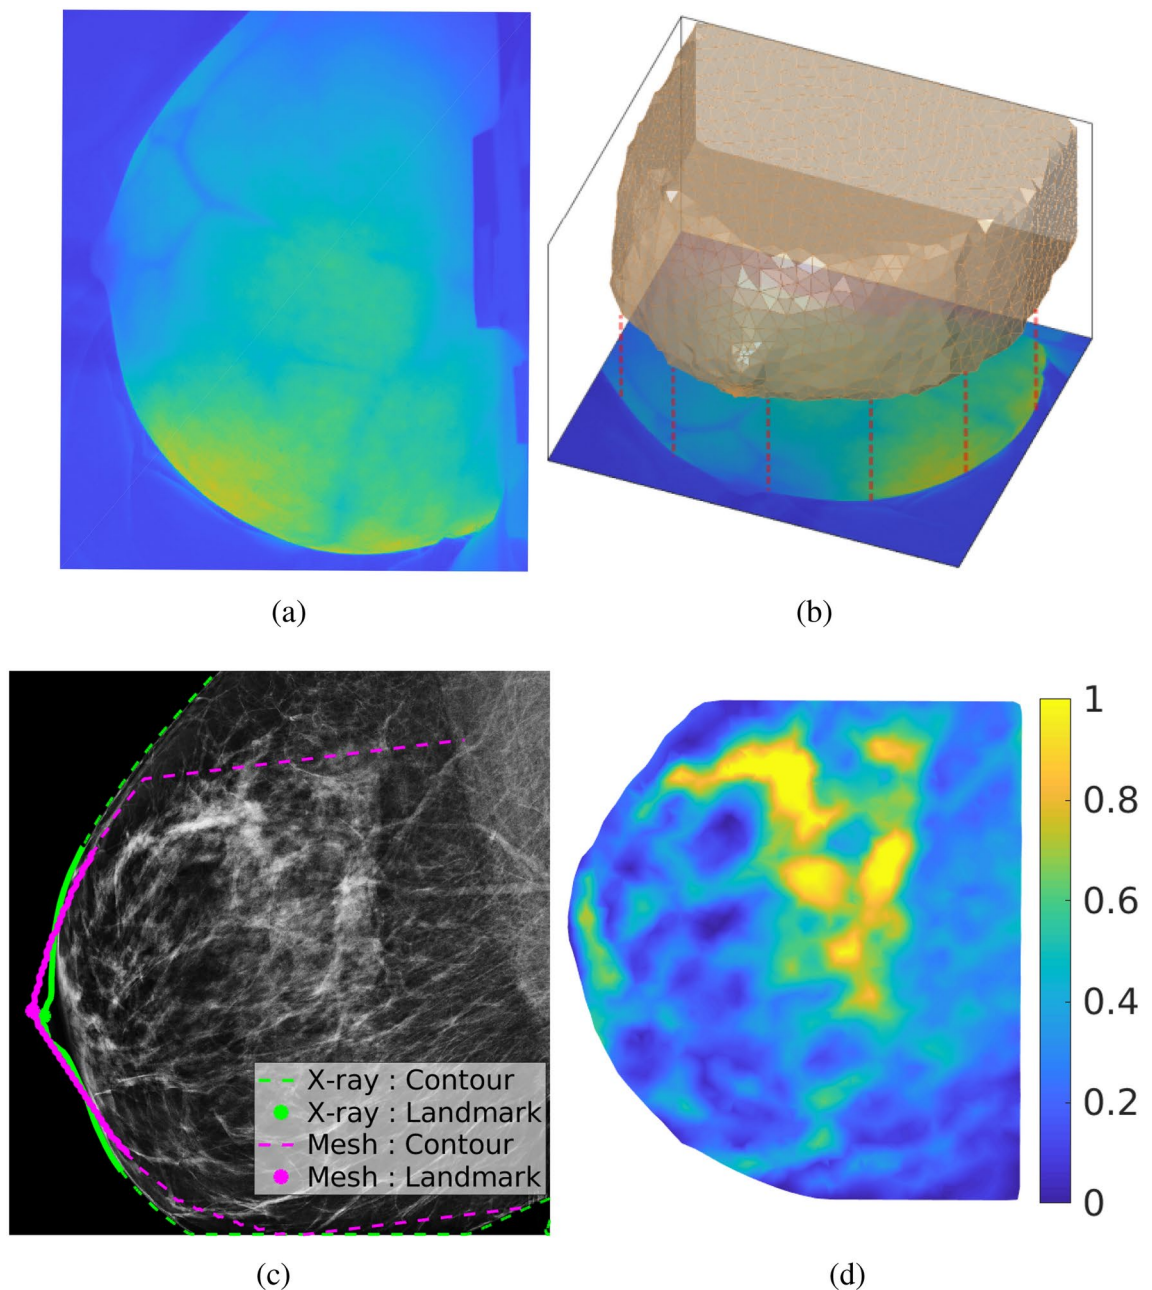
Example optical and x-ray images acquired from a normal breast, showing (a) diffuse transmittance image using full-white illumination acquired by the camera, (b) a tetrahedral breast mesh co-registered with the camera image, (c) separately acquired mammogram of the same breast, with co-registered breast contours extracted from the breast mesh (magenta) and mammogram (green), and (d) compositional prior of the fibroglandular tissue (as volume fraction) derived from the mammogram. The breast contour registration is performed using an iterative closest-point (ICP) algorithm by matching the solid-line portions from both the x-ray and mesh derived contours.
